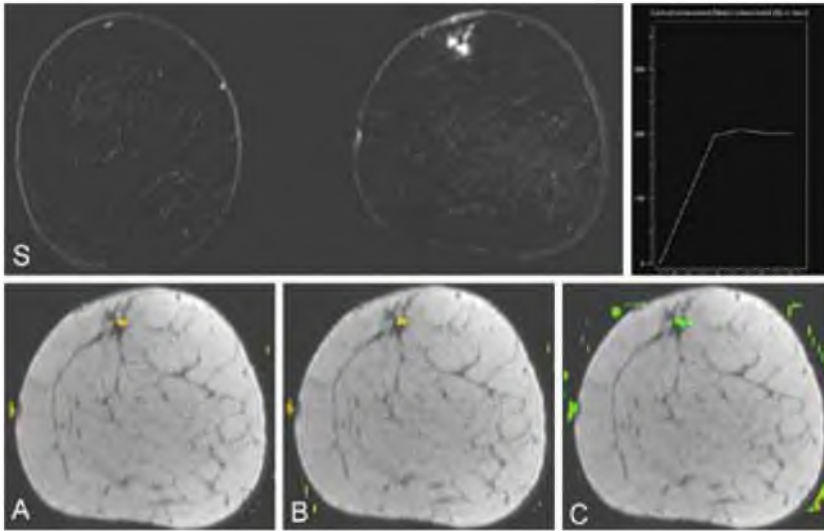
Subtraction image of both breasts (S). There is a suspicious enhancing lesion in the left breast. The signal intensity versus time curve shows a plateau. Color-coded parametric maps of K^{trans} (A), k_{ep} (B) and v_e (C), projected over T1-weighted images of the affected breast, are not suspicious for malignancy. At pathology the lesion proved to be chronic inflammation.
